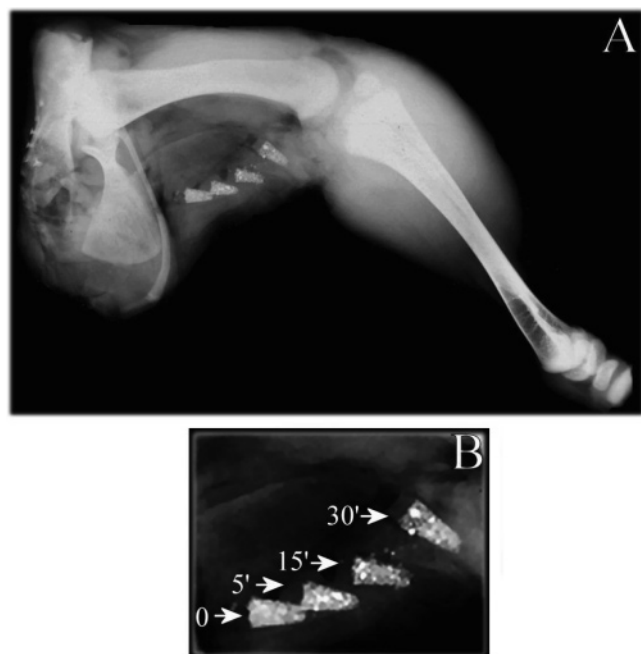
(A) X-ray of the chicken leg with four different samples of the radio-opaque microparticles, embedded in gelatin as a mimic for the filler agent used clinically, implanted in the soft tissue part (see text). (B) Expansion of the soft-tissue containing the four samples.
